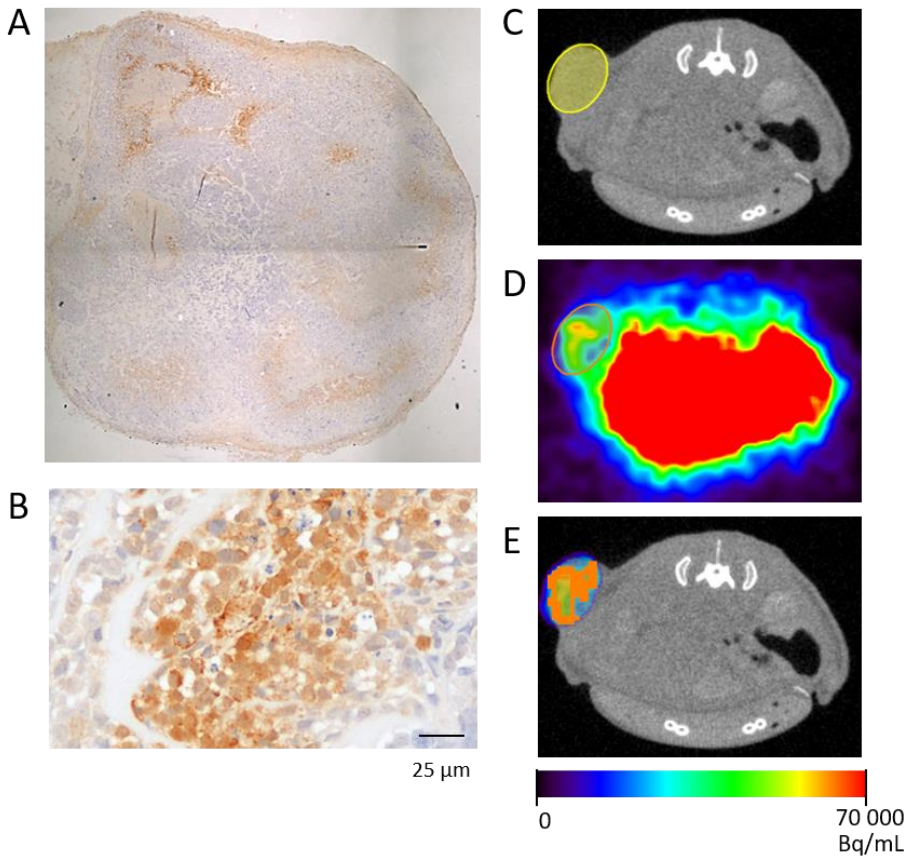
$^{18}\text{F}$ -FAZA PET/CT.
